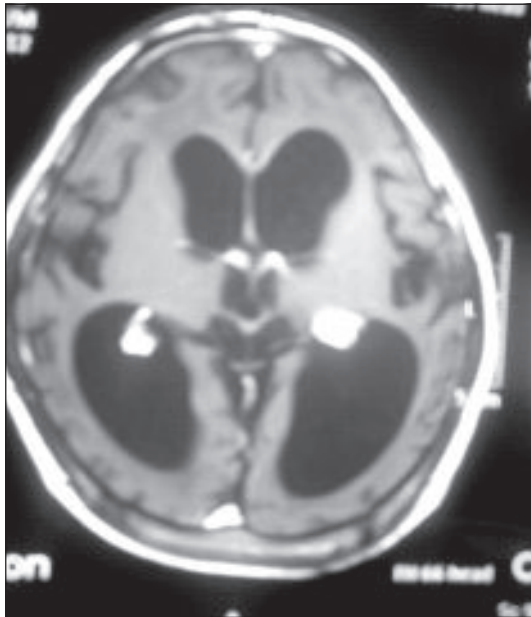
CT scan of brain showing communicating hydrocephalus.
